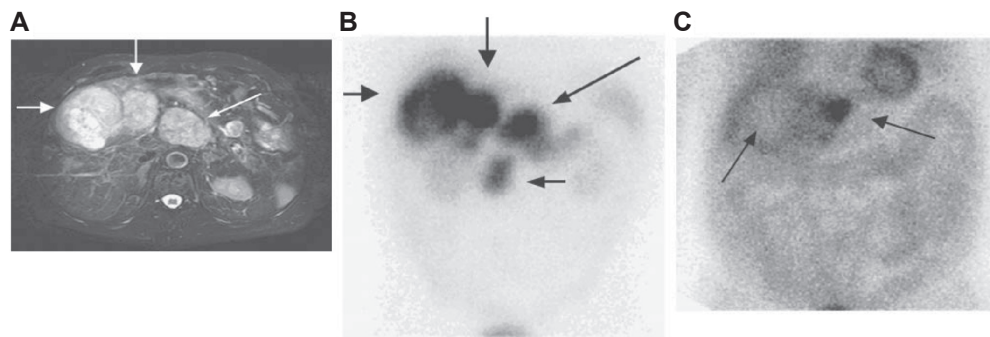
MRI (A), ¹¹¹In-pentetreotide (B), and ¹²³I-MIBG (C) scans of a patient with metastatic nonfunctioning P-NET demonstrate intense tracer uptake in liver and lymph node metastases and the large primary lesion (A and B, arrows). These findings are in contrast to the virtually negative MIBG scan, which shows only low uptake in 1 metastatic lesion in left liver lobe (C, arrow to right), with rest of tumor lesions being negative; note the cold area (C, thin arrow) in the right liver lobe corresponding to the major metastatic site. Copyright © 2006. Reprinted by permission of the Society of Nuclear Medicine from Ezziddin S, Logvinski T, Yong-Hing C, et al Factors predicting tracer uptake in somatostatin receptor and MIBG scintigraphy of metastatic gastroenteropancreatic neuroendocrine tumors. *J Nucl Med.* 2006; 47(2):223–233.
